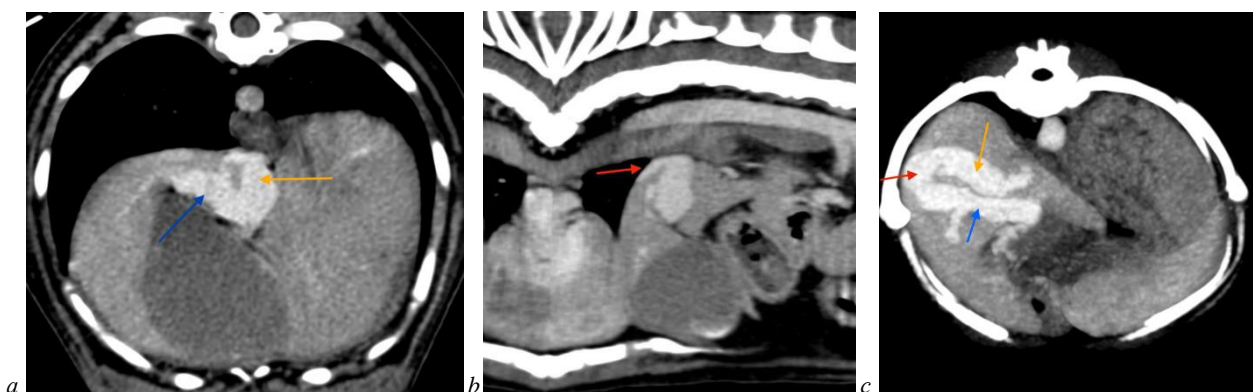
Computed tomography of the intrahepatic portosystemic shunt: *a* – yellow arrow indicates vena cava caudalis, blue arrow – drainage from vena portae into vena cava caudalis; *b* – red arrow – shunting vessel; *c* – blue arrow – vena portae; yellow arrow – vena cava caudalis, red arrow – shunting vessel
